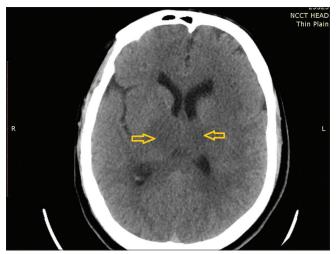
Plain computed tomography axial image showing hypodense appearance of the bilateral gangliothalamic region (marked with yellow arrows)
